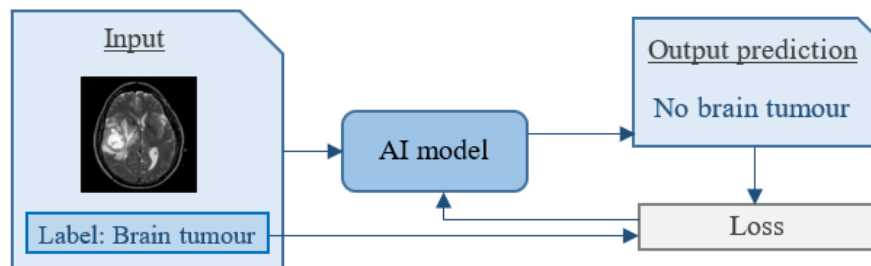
Outline of the supervised learning process. Input data is presented to the AI model. In this example the model is trained to recognize brain tumours in MR images. Based on the input data the AI model makes a prediction. When the prediction is incorrect, the loss between the label and the prediction will cause the model to change its model parameters to achieve the best performance.
